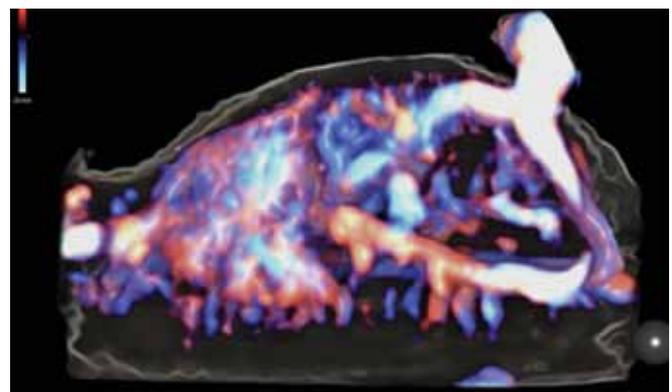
Fetal pulmonary sonoangiogram at 13 weeks of gestation. Fetal intracorporeal angiostructure is demonstrated by 3D HDlive silhouette/flow imaging with bidirectional power Doppler at 13 weeks of gestation. The umbilical arteries, umbilical vein, ductus venosus, inferior vena cava, descending aorta as well as rich pulmonary vascularity are clearly demonstrated in a single 3D reconstructed image. This image indicates existence of rich pulmonary vascularity from even before lung maturation in the first trimester
